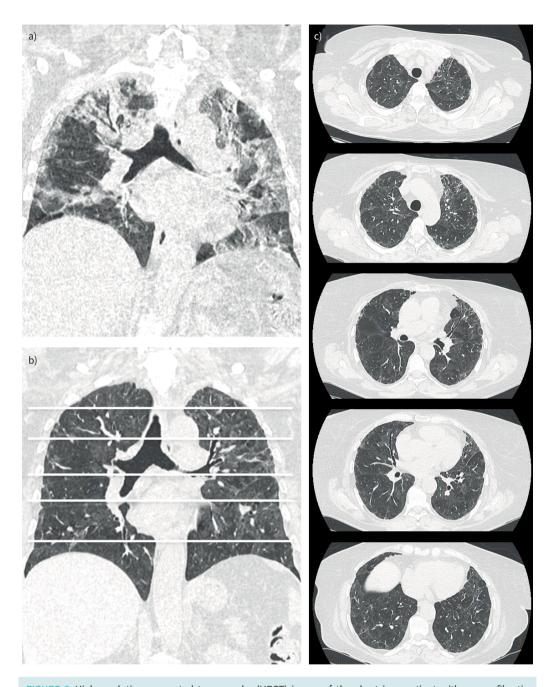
High-resolution computed tomography (HRCT) image of the chest in a patient with severe fibrotic lung lesions 4 months after hospitalisation for coronavirus disease 2019 (COVID-19) compared with that during acute COVID-19. Coronal a) multiplanar reconstruction of an HRCT image of the chest during acute COVID-19 with extensive bilateral ground-glass opacities and consolidations. Coronal b) multiplanar reconstructions and axial sections c) of an HRCT image of the chest from the same patient showing severe fibrotic lung lesions at 4 months, demonstrating diffuse traction bronchiectasis and association with ground-glass opacities.
